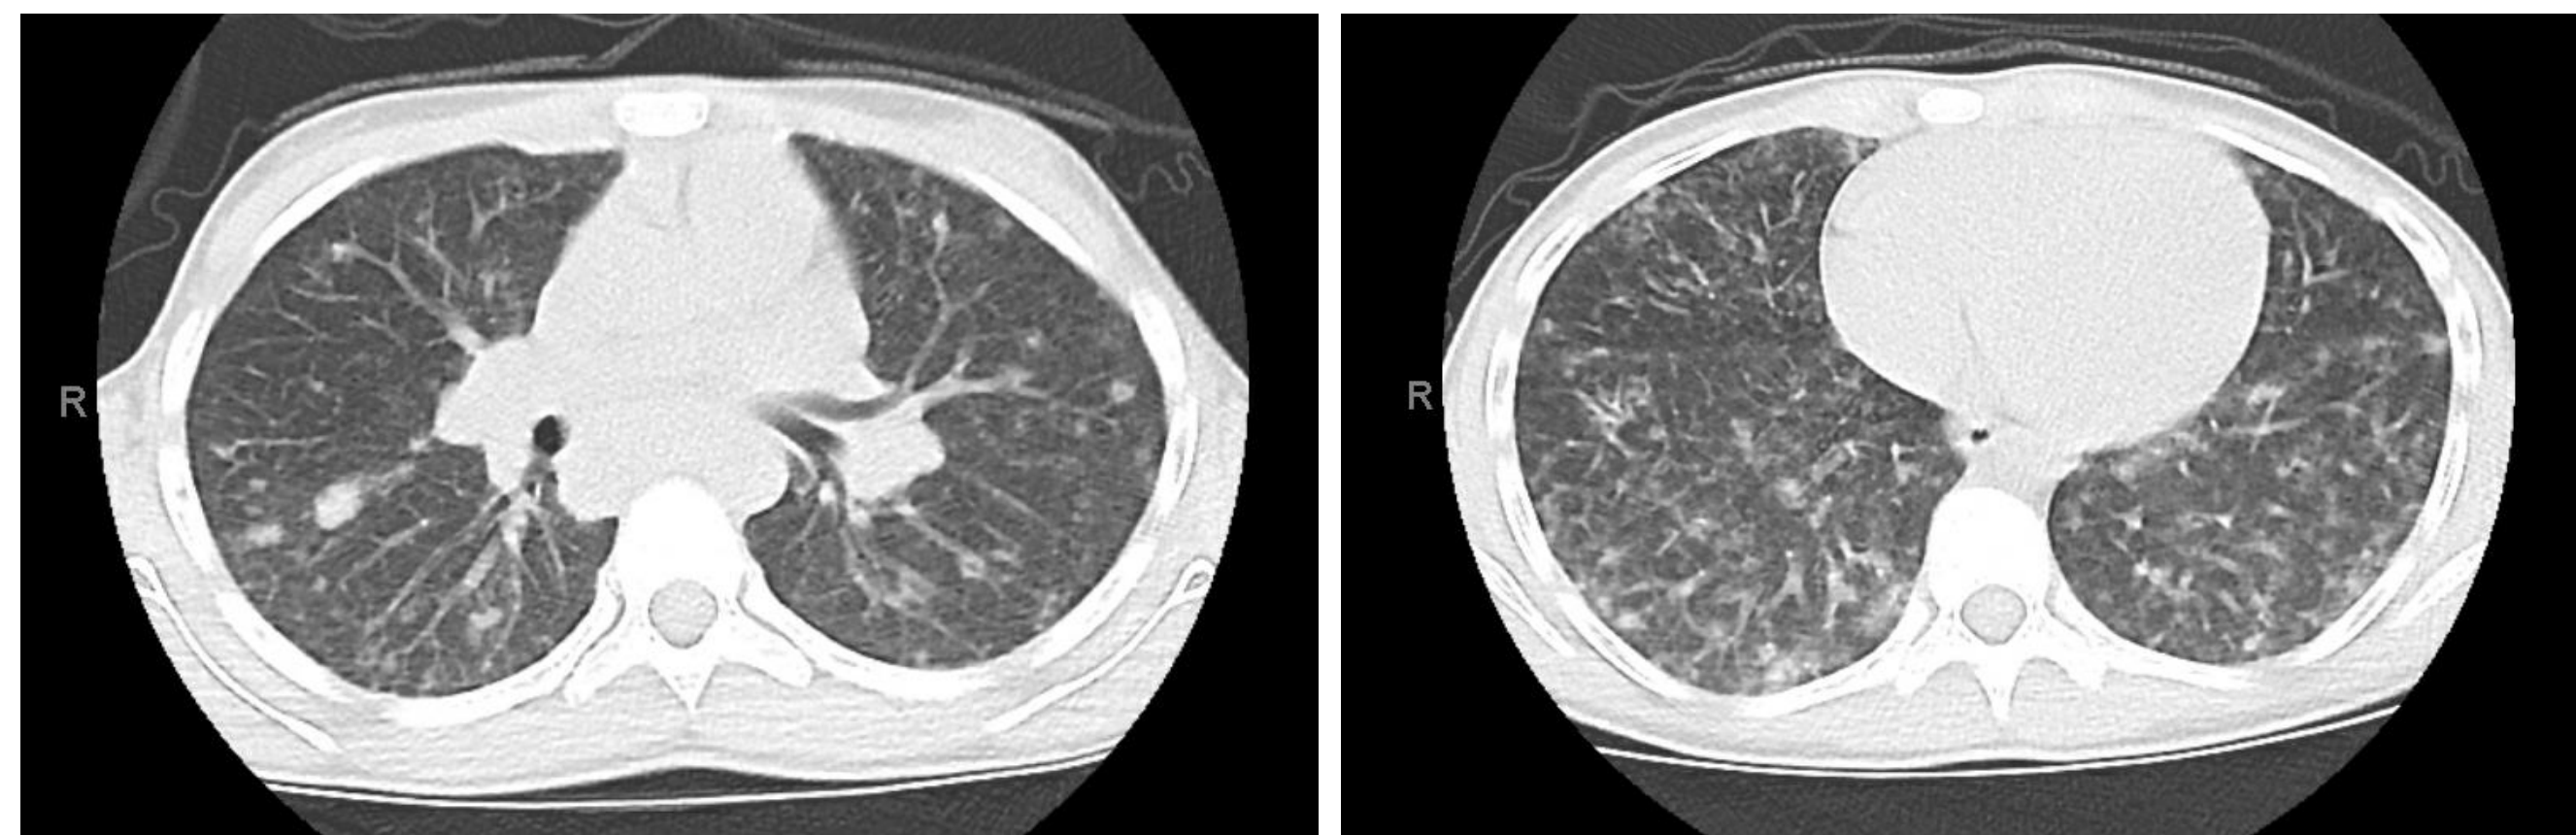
HRCT showing reticulonodular interstitial infiltrates with multiple superimposed pulmonary nodules
